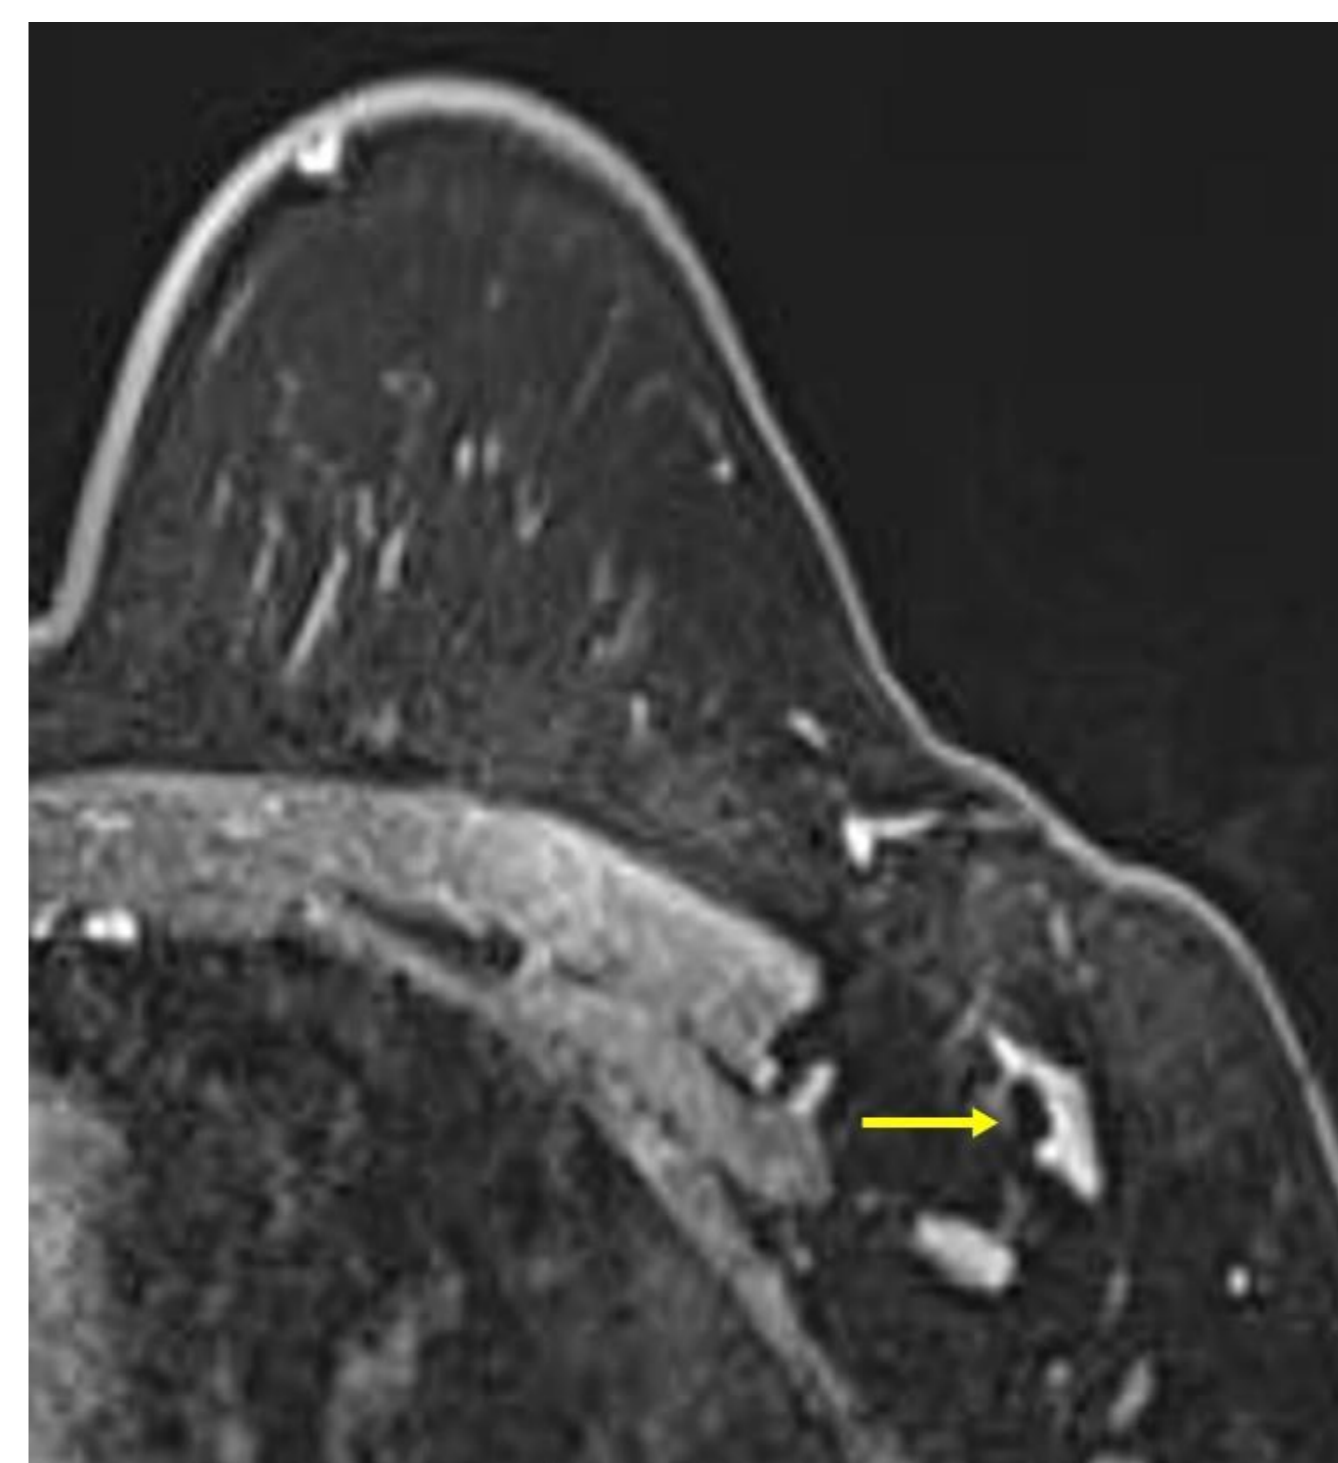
MRI axial T1-weighted, gradient echo, volumetric-interpolated examination, fat-saturated, post-contrast axial image: The reflector (arrow) was inserted in a metastatic left axillary node. It appears as a thickened linear hypointense object without significant blooming artefact. It did not obscure visibility of the underlying node.
